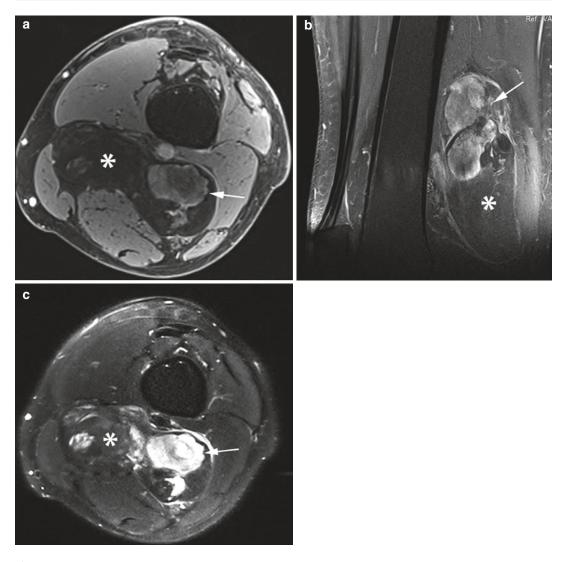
(a–c) Dedifferentiated liposarcoma of the left thigh. (a) Axial. (b) Sagittal fat-suppressed SE T2-weighted images. (c) Axial fat-suppressed SE T1-weighted after Gd-contrast injection MR image. Parts of the mass show fat SI (*) (a–c), but a large irregular
